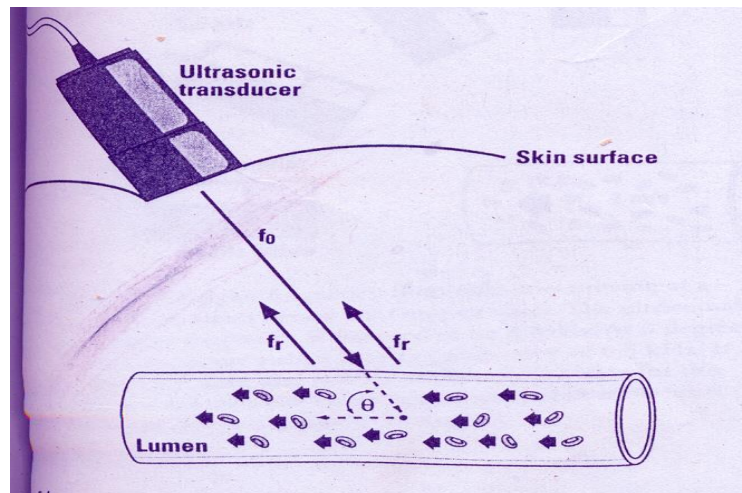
shows arrangement for detecting Doppler signals from vessel, where  $\theta$  is the Doppler angle (Zagzebski, 1996).
